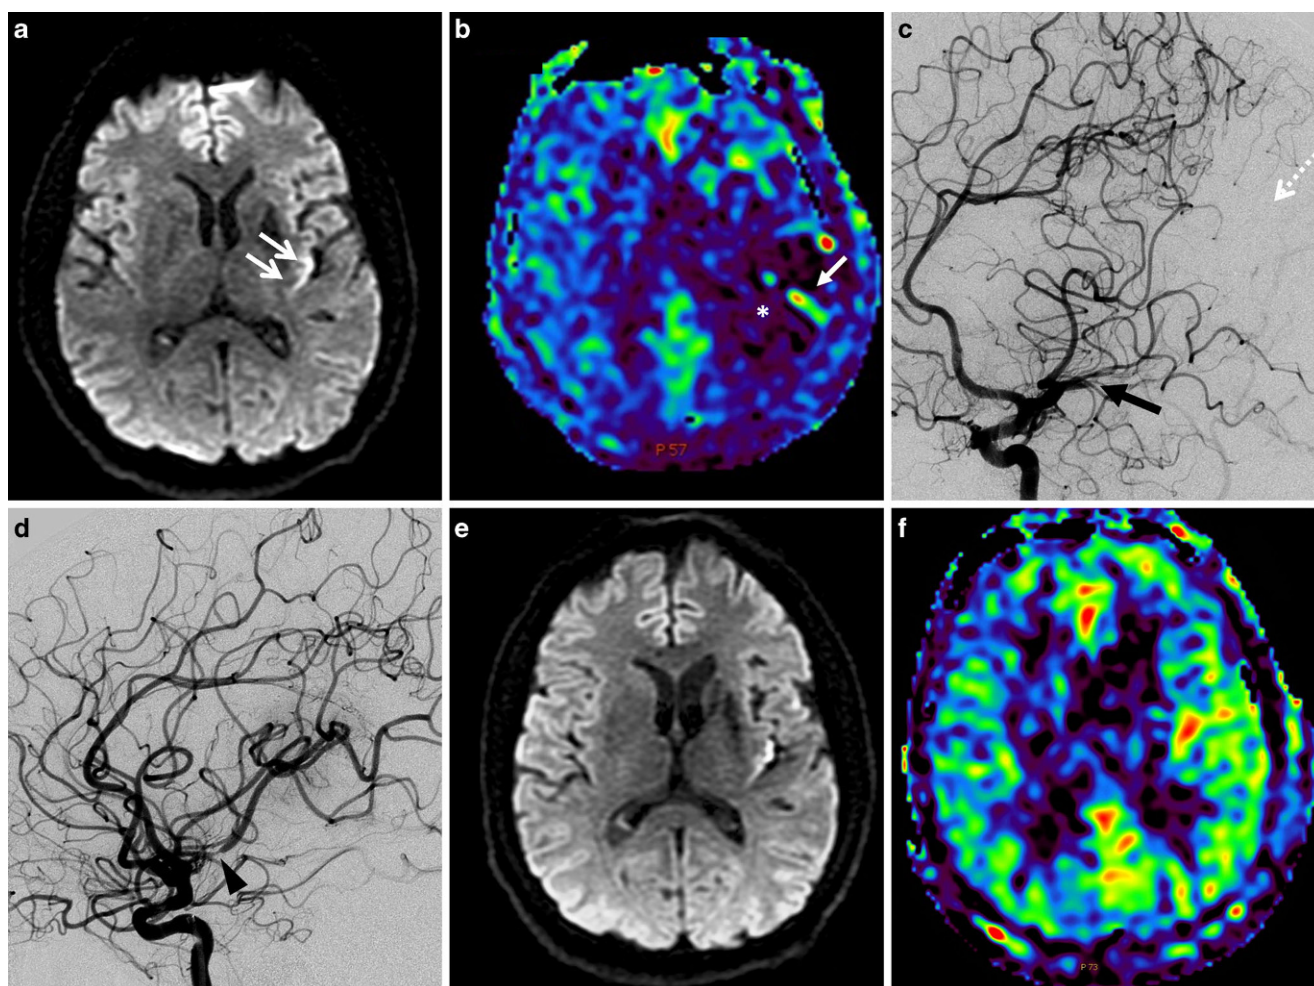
A 50-year-old patient with acute onset aphasia and partial motor deficit (National Institute of Health Stroke Scale 6) due to a left M2 occlusion who underwent intravenous thrombolysis and mechanical thrombectomy (MT) at 3 h from symptoms' onset. a Diffusion weighted imaging (DWI); axial slice showing small insular and opercular acute ischemic stroke (*white arrows*). b Arterial spin labelling (ASL) perfusion sequence displaying a large hypoperfusion (*white asterisk*) in the occluded territory assessing the DWI-perfusion mismatch. Note the linear hyperperfusion corresponding to a transit arterial artifact, related to slowdown in a cortical branch (*white arrow*). c Left internal carotid artery selective DSA (Digital Subtraction Angiography) in left anterior oblique (LAO) projection: inferior division M2 branch occlusion (*black arrow*) with arterial defect in the corresponding territory (*white dotted arrow*) are seen. d Control DSA after two thromboaspiration attempts: Thrombolysis In Cerebral Infarction score 2b recanalization 26 minutes after groin puncture. Note the significant spasm at the occlusion's level (*arrowhead*). e Control MRI (Magnetic Resonance Imaging) 24 h after MT, DWI; axial slice: no extension of ischemia is seen. f ASL perfusion sequence at day 1 showing complete reperfusion of the posterior MCA territory defect. Note the faint hyperperfusion of the previously hypoperfused territory, also known as "luxury perfusion"
